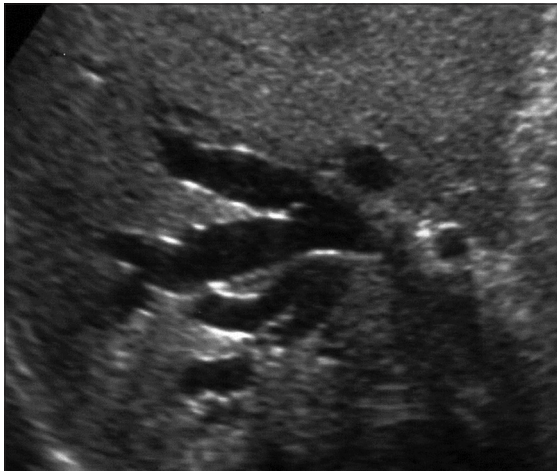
Ultrasonography showing dilated central intra-hepatic duct with tapering toward periphery
